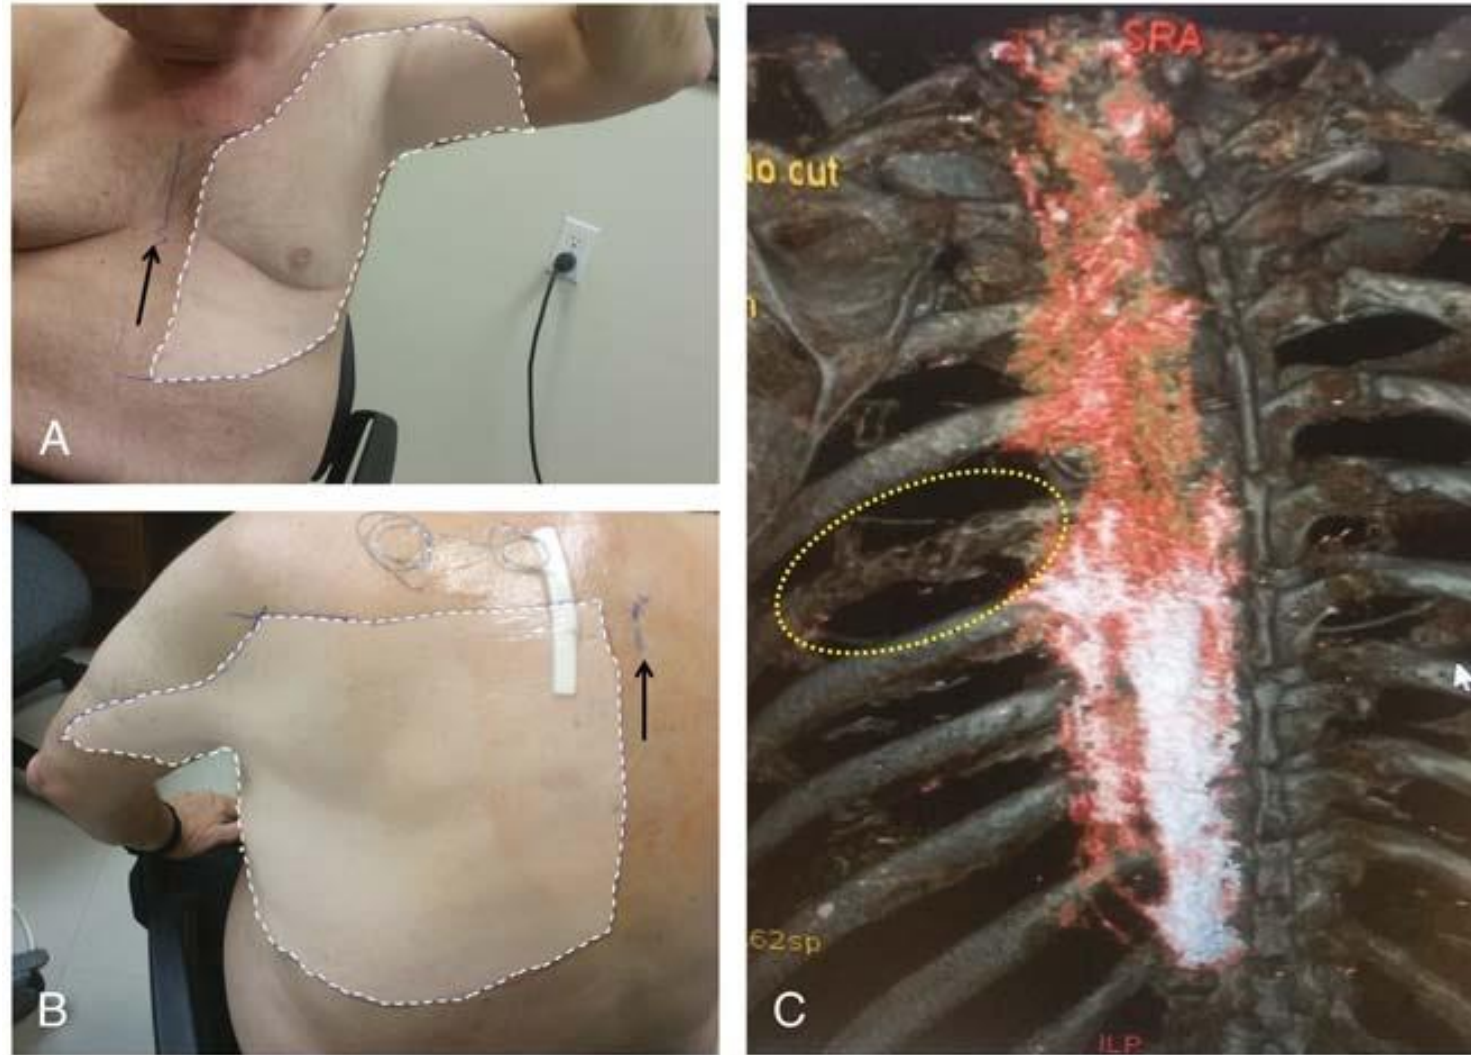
Extent of cutaneous sensory loss over the anterior (A) and posterior thorax (B) in the first patient of the case series, which was consistently reproduced each time the block was performed. The black arrows indicate the location of the midline. Note the site of catheter insertion approximately 3 cm lateral to the midline. C, Three-dimensional CT reconstruction demonstrating extensive cephalocaudal spread of injectate from T1 to T11 vertebrae after injection of 25 mL of fluid superficial to erector spinae muscle at T5. There is spread medially toward the midline but limited lateral spread. The dotted ellipse highlights the lytic lesion of the sixth rib causing the patient's pain.
